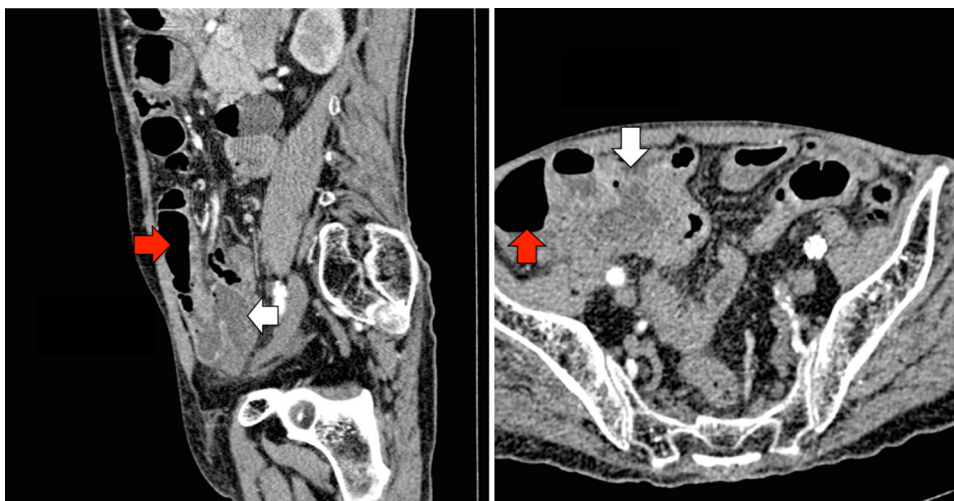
Computed tomography of the abdomen evidencing an agglomeration of small bowel loops (white arrows) with upstream dilation (red arrows).
